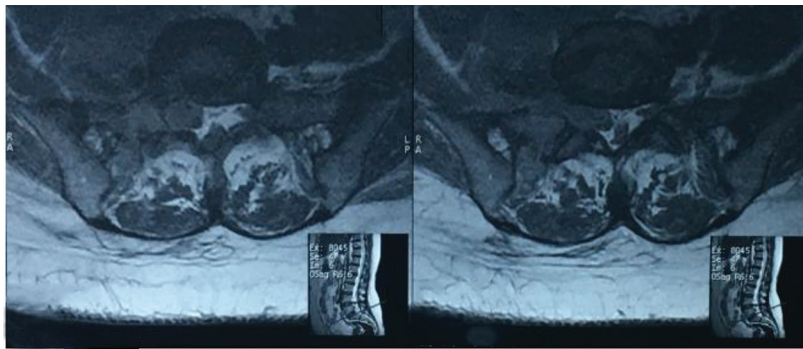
Axial MRI view at L5 and S1 level. The tumor expanded the right S1 foramina and extended into the retroperitoneal space. MRI, magnetic resonance imaging.
